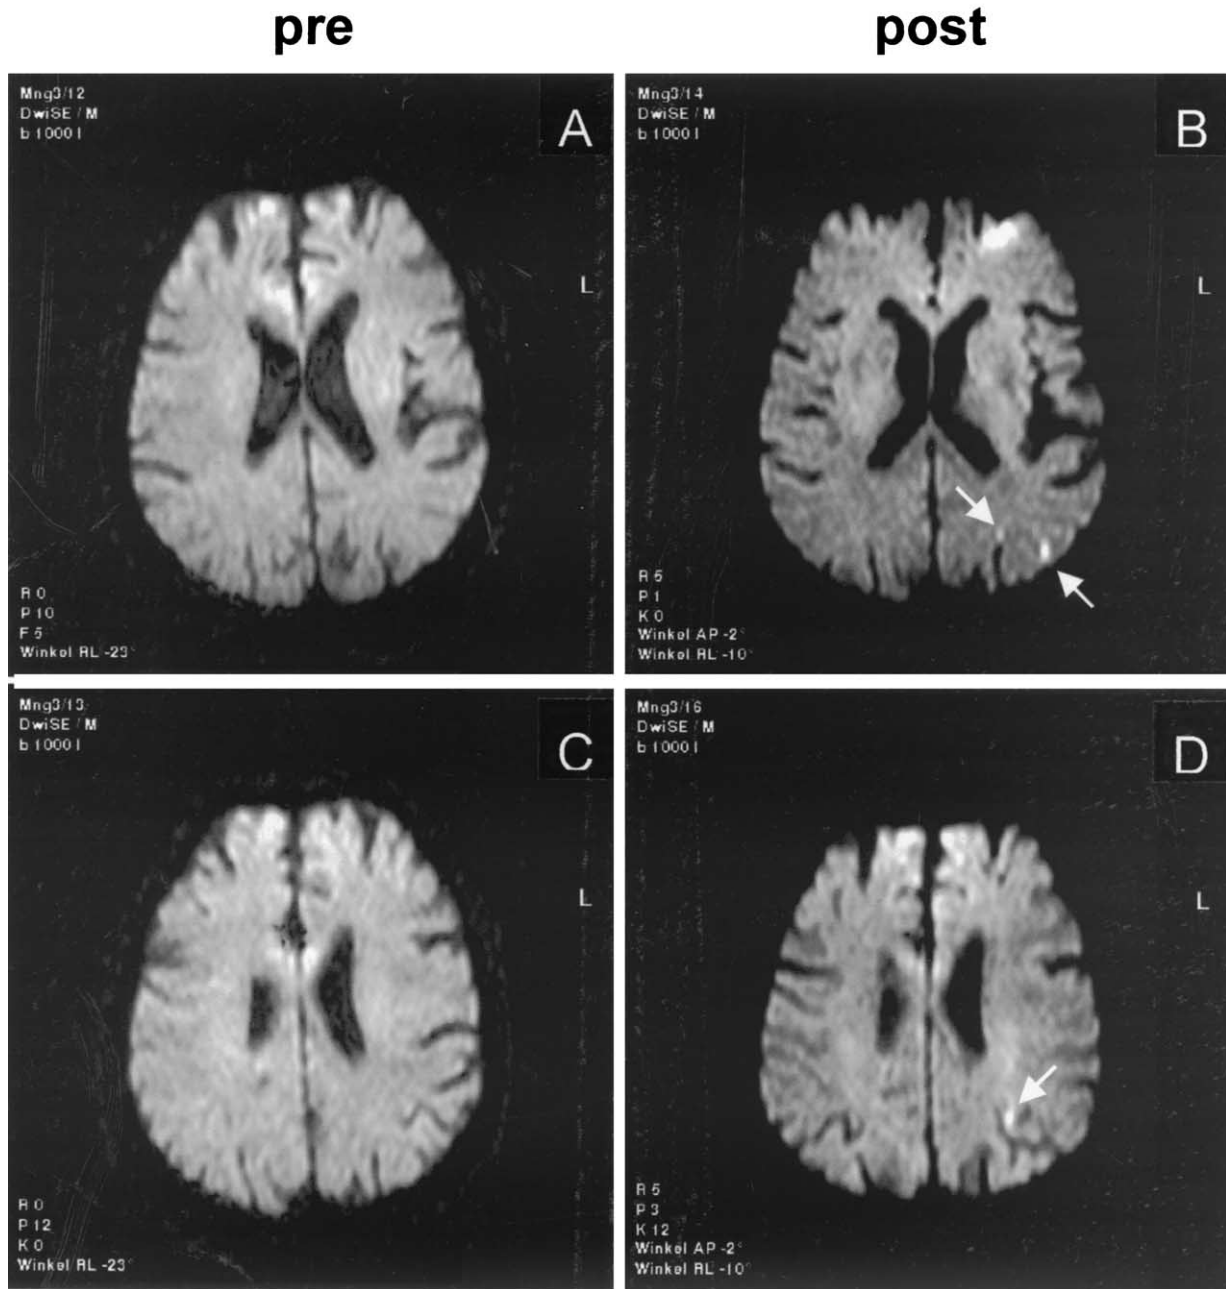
Magnetic resonance imaging scans showing three ischemic lesions (arrows in panels B and D) in adjacent tomographic layers of the left posterior midbrain in Patient #5 (Table 2, first intervention). Corresponding preinterventional MRI scans in panels A and C.
